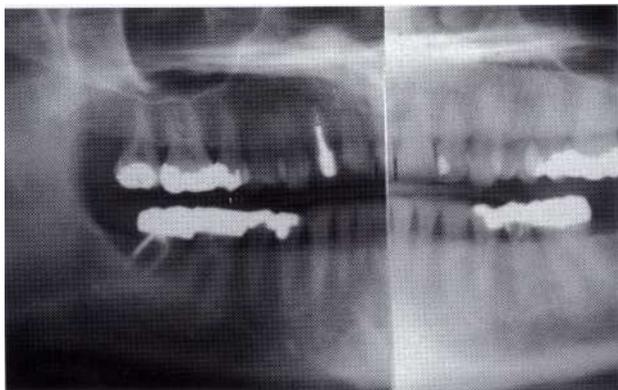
Preextraction Panorex radiograph of tooth #7 with apical lesion.
